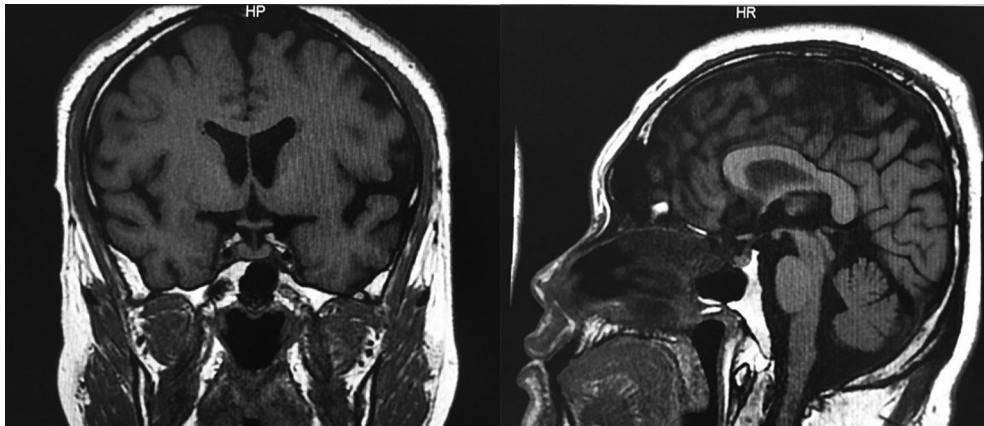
Pituitary magnetic resonance image.
